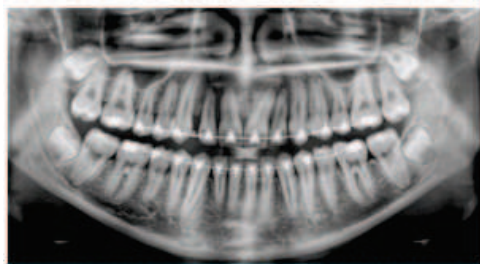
Example of a diagnostically acceptable panoramic radiograph of an adolescent patient undergoing orthodontic intervention. (Courtesy of Jamie Mace and Will Wright of Schick Technologies Inc.)
